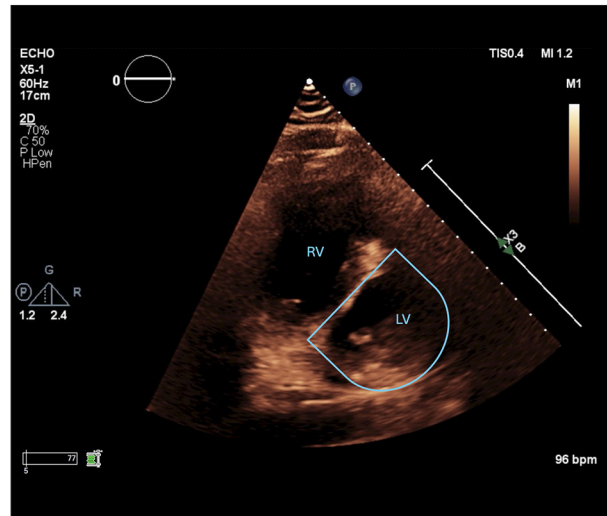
Transthoracic echocardiography (parasternal short axis) demonstrating the classic D-sign, characterized by interventricular septal flattening that results in a D-shaped left ventricle during diastole, consistent with right ventricular volume overload.
